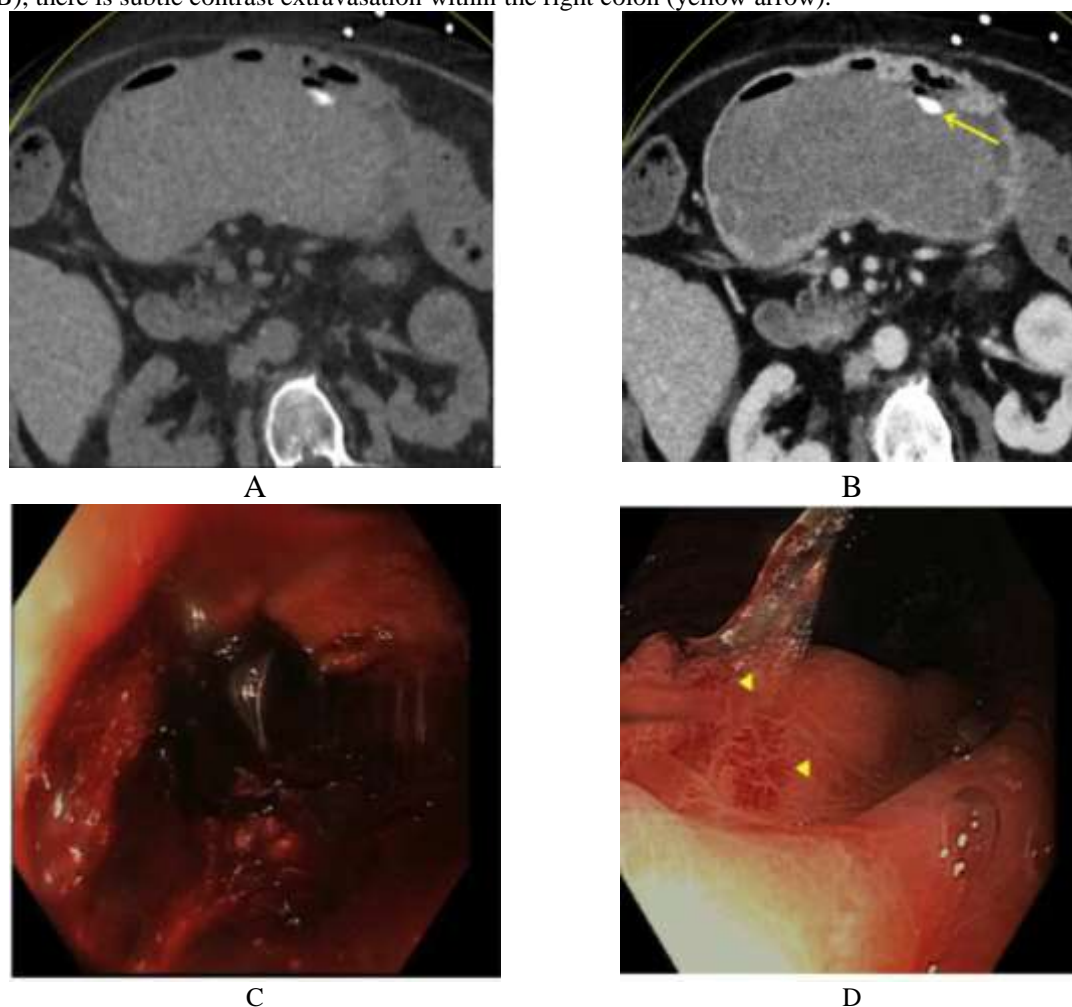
73-year-old female with hematemesis and bright red blood per rectum who underwent dual energy CT. Virtual non-contrast (A) and portal venous phase (B) images demonstrate a large volume of hyperdense clot within the gastric lumen. No active extravasation is seen, however there is an ingested pill within the stomach (yellow arrow). Subsequent endoscopy confirmed a large volume of blood within the stomach (C), as well as multiple bleeding arterio-venous malformations (yellow arrowheads, D).
